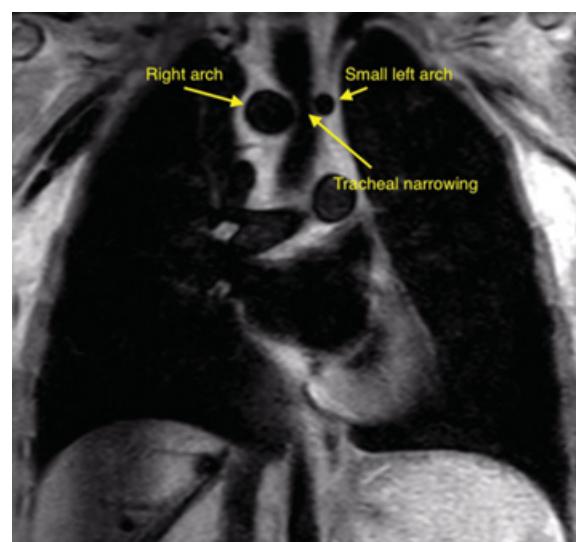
Double aortic arch. Coronal black blood magnetic resonance image showing left-right narrowing of the trachea by the double aortic arch. Courtesy of Michael Taylor, MD.
